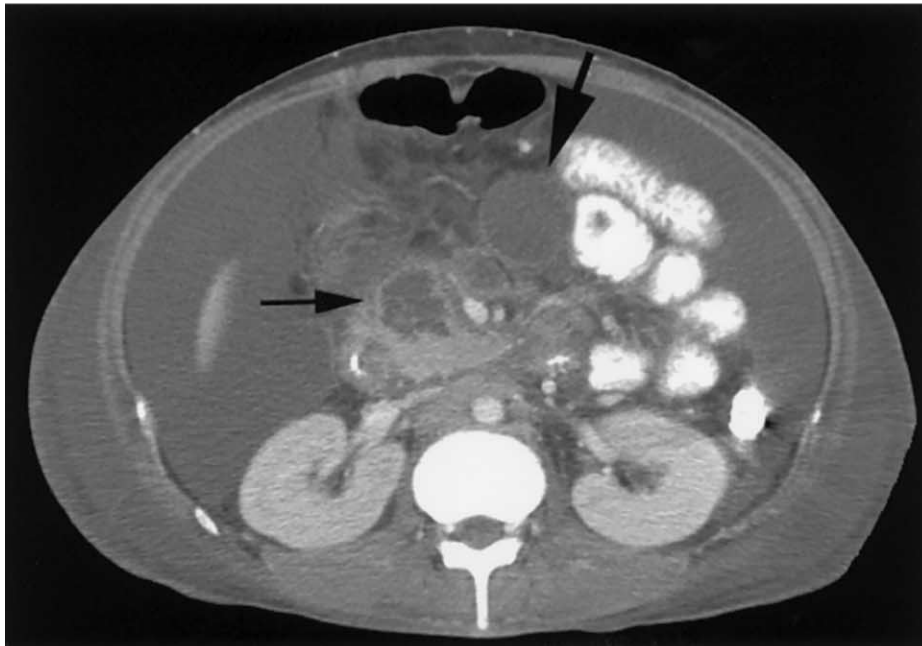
A, CT scan from hospital day 4. The *small arrow* indicates a normal pancreas (compare with B). The *large arrow* points to the cyst that was subsequently thought to be a pseudocyst. Also, note the large amount of ascites around the liver. B, CT scan from hospital day 9. The *small arrow* now indicates the necrotic pancreas. The *large arrow* points to the same cyst indicated in A. Note the increase in the amount of ascites.
